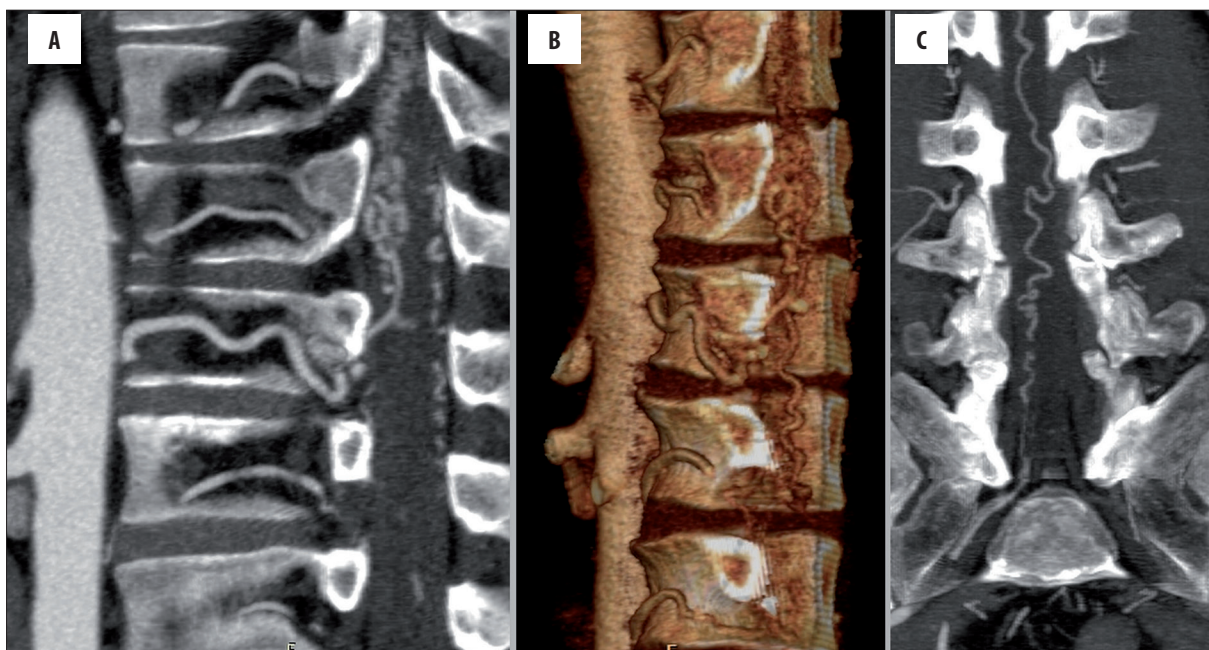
Sagittal curved planar reformat of (A) and volume rendered image of CTA (B) demonstrate the artery of Adamkiewicz feeding the AVM. Coronal curved reformat (C) showing drainage of the AVM through right 1st sacral foramen via an elongated tortuous vein.
